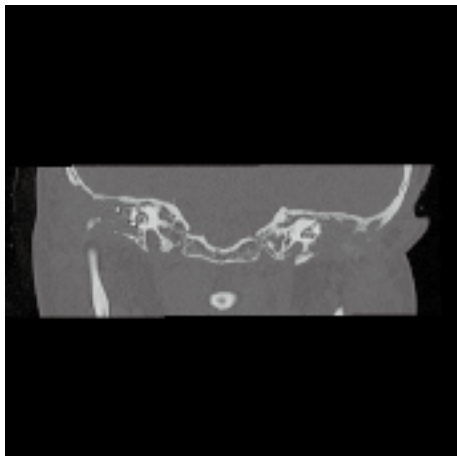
Postoperative CT of temporal bone demonstrating correct positioning of electrode array.
